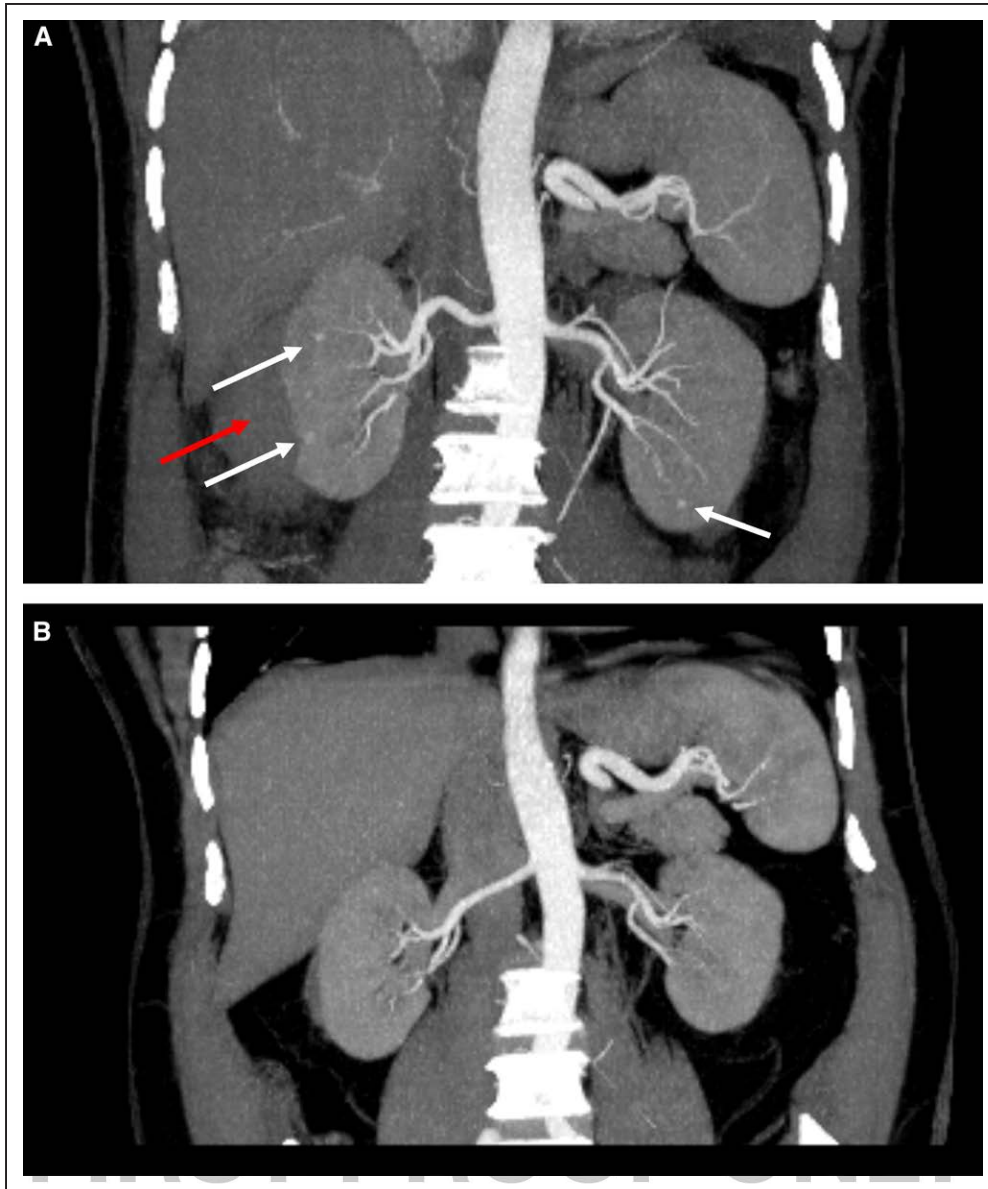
Computed tomography angiography (CTA) in polyarteritis nodosa. A, Coronal maximum intensity projection CTA demonstrating bilateral intrarenal microaneurysms (white arrows) and a large right subcapsular perinephric hematoma (red arrow). B, Repeat CTA 6 mo later following immunosuppressive treatment and achievement of clinical remission shows resolution of radiological changes.
